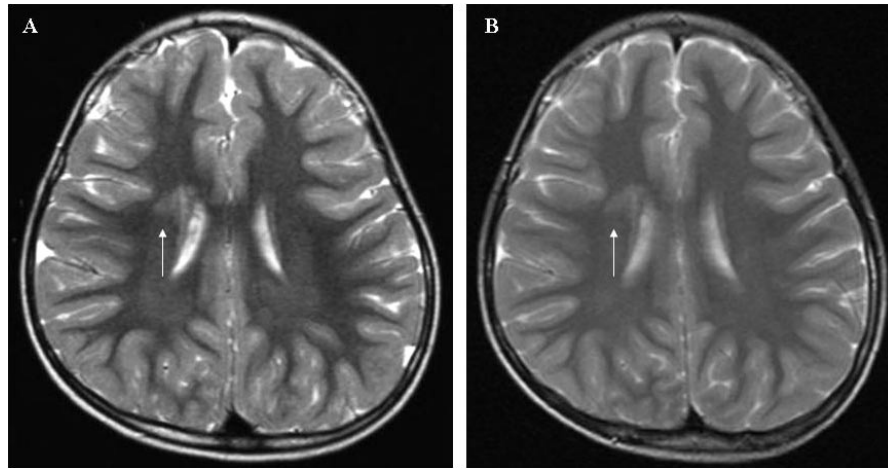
Transverse T₂-weighted brain MRI showing a confluent hyperintense lesion in the right frontal lobe in Patient FC55 (II-2) with an R364W *MFN2* mutation. The abnormalities observed in T₂-weighted sequences showed no interval change between 3 (A) and 6 years of age (B).
